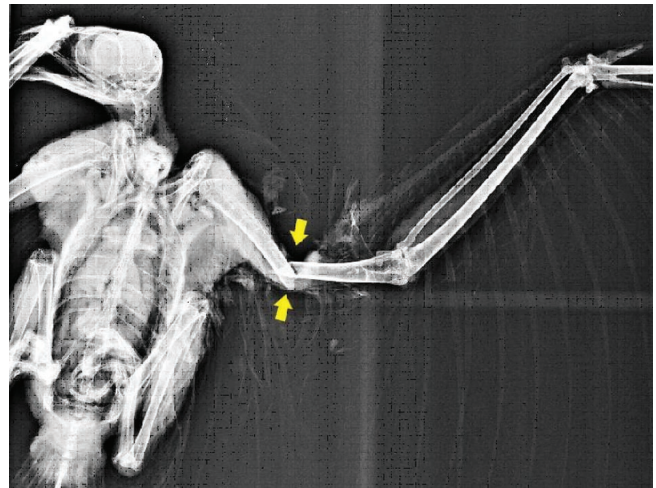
Radiograph of the left wing of Black kite showing complete oblique, mid-diaphyseal fracture of humerus (arrow).
